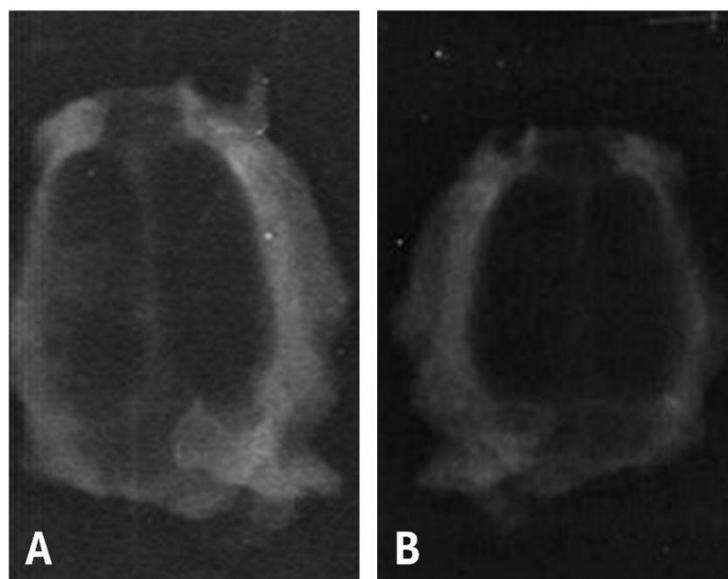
The detection of mineral loss in radiographic imaging from the initiation of decalcification solution application on day 1 (A) and until the complete decalcification (B).
